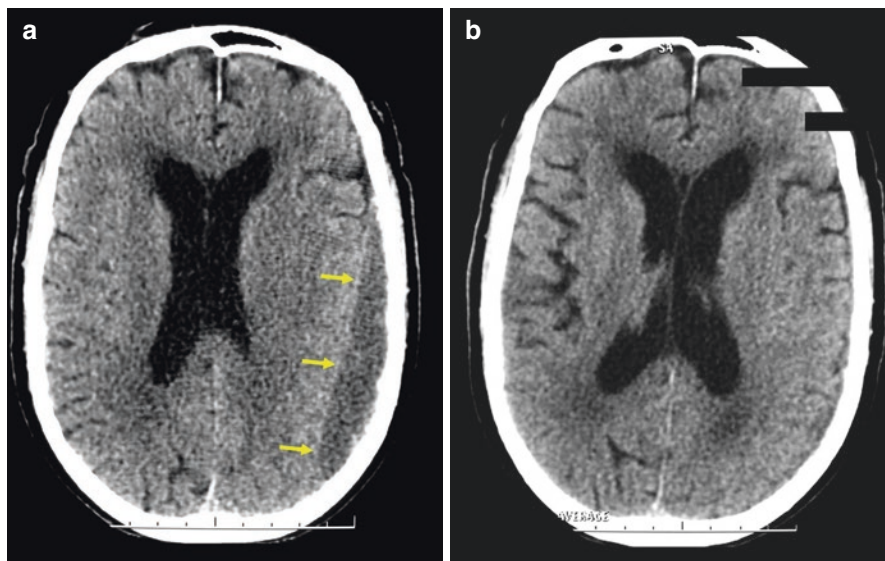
Paucisymptomatic intracranial chronic SDH in 72-year-old man treated by corticosteroids and oral rehydration for 6 weeks. Initial CT scan (a) and control CT scan 2 months later showing the disappearance of the hematoma (b)
